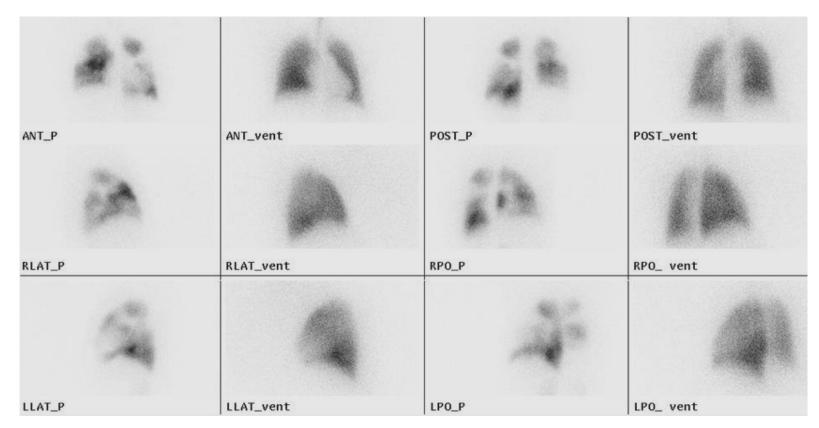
Case Two (Below V/Q SPECT MIP images)
